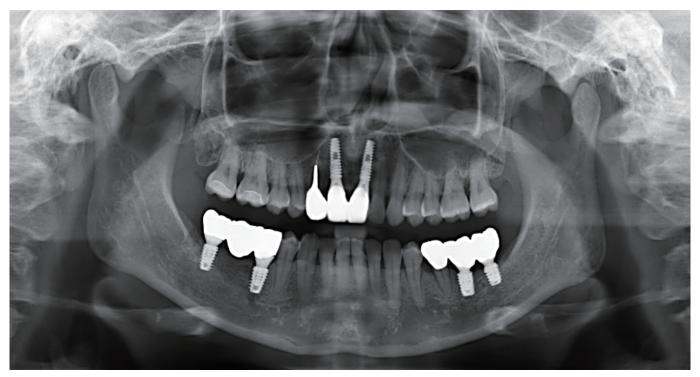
Post-op panoramic x-ray after 11 months.
